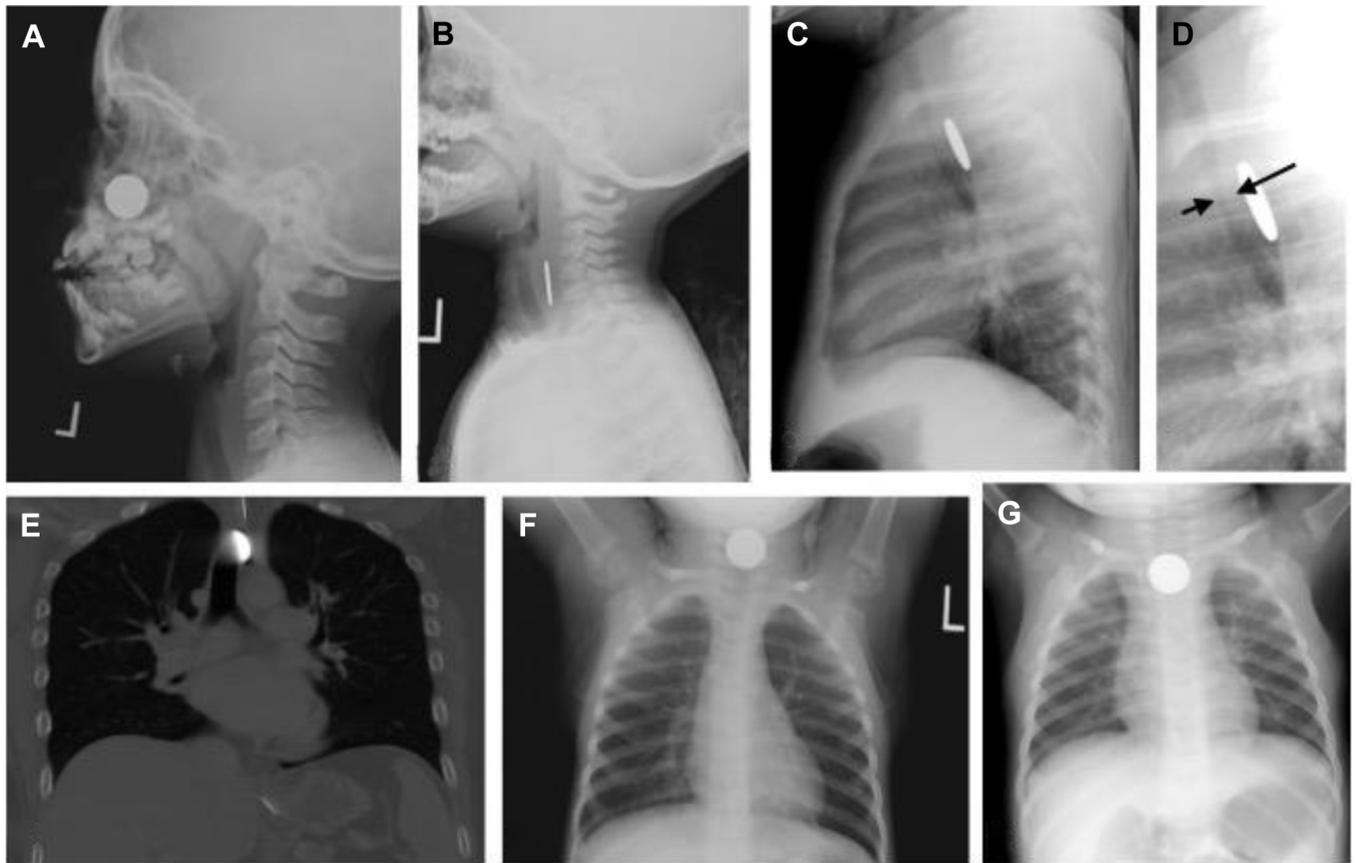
Ingested coins, with common sites of impaction. *A*, Coin in the nasal cavity of a 5-year-old boy who was thought to have swallowed a coin. *B*, Lateral radiograph with a coin in the cervical esophagus, at the level of the cricopharyngeus, the most common area for impaction. *C*, Lateral radiograph in a 16-month-old with 2 days of choking and gagging. The coin is seen in the esophagus at the level of the aortic arch. Magnified view in the same patient (*D*) shows anterior esophageal thickening in this region and effacement of the posterior aspect of the trachea (black solid arrows). This suggests local esophageal edema from irritation, compatible with 2-day history since ingestion. *E*, Coronal CT showing how an esophageal coin can perch and impact at the level of the aortic arch. *F*, PA view with inferior margin of the coin at the level of the cricopharyngeus. *G*, PA view with inferior margin of the coin at the level of the aortic arch.
